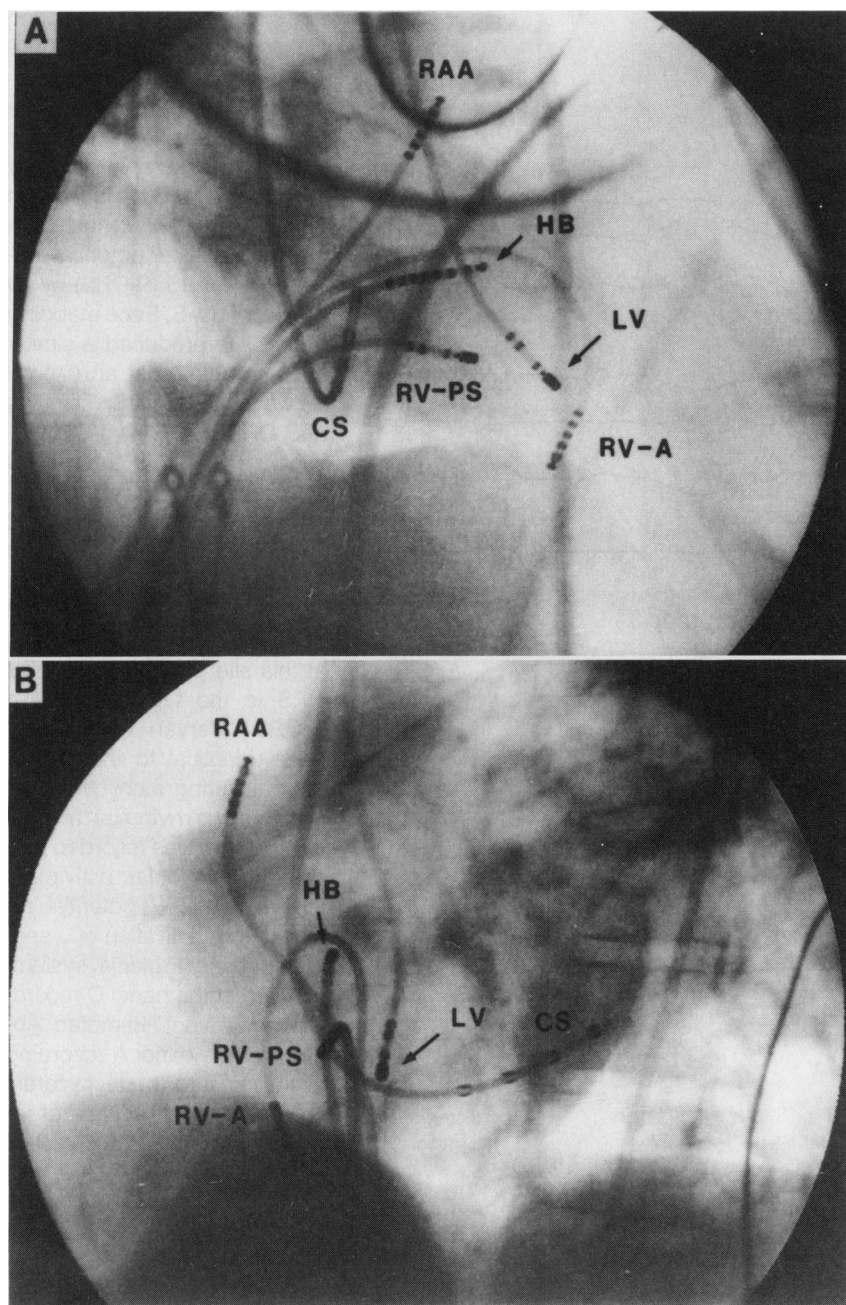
Radiographs in the right anterior oblique projection (A) and left anterior oblique projection (B) showing the location of the left ventricular catheter (LV) at the ablation site in patient 6. The large-tip electrode is positioned at the posterior left ventricular septum, one third of the distance from apex to base. The other five catheters were located near the right atrial appendage (RAA), His bundle region (HB), coronary sinus (CS), right ventricular apex (RV-A), and right ventricular posterior septum (RV-PS), and electrograms are shown in the upper panels of Fig 2.
